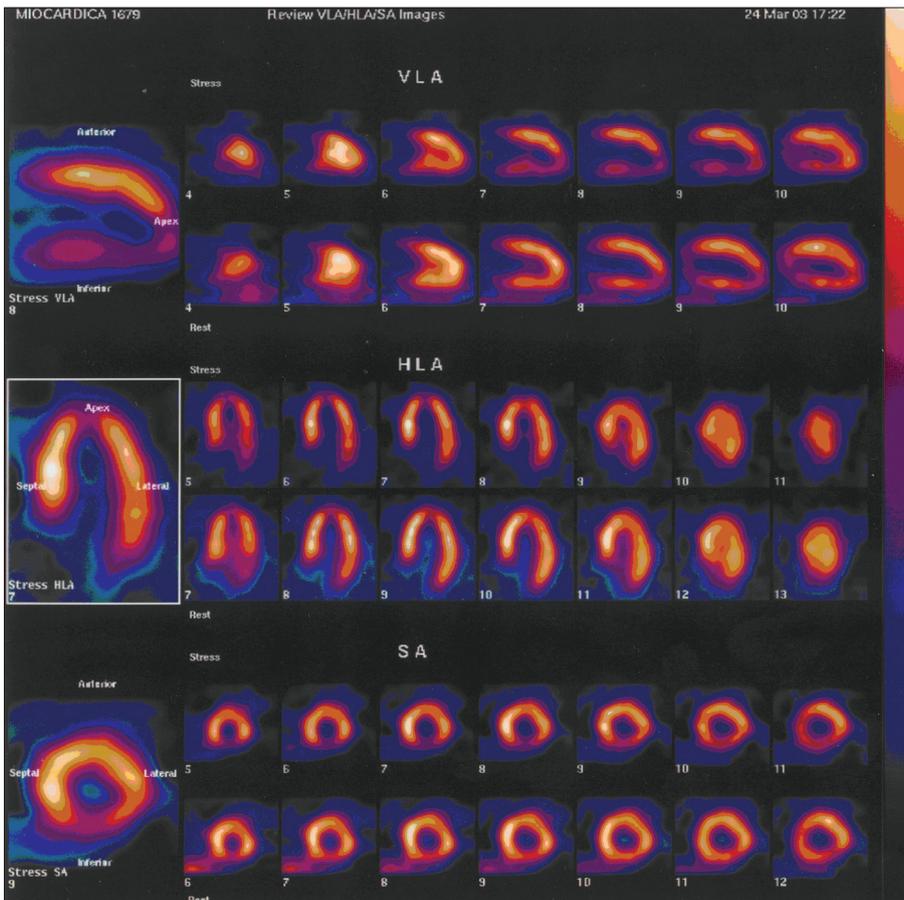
Myocardial perfusion SPECT stress images demonstrated a wide infero-apical defect; rest scan, obtained two days later, showed a recovery of perfusion in the infero-apical segments.
